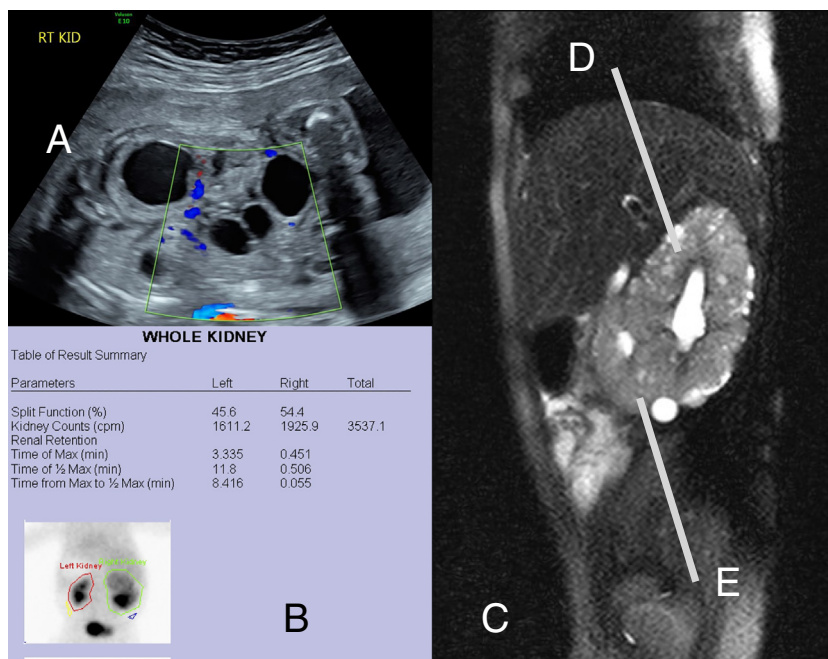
Antenatally suspected large right MCDK, postnatally large upper moiety MCDK with hidden lower moiety with preserved function. A: Antenatal USS appearance of right suspected MCDK at 30 weeks gestation. B: Mag 3 shows previously undetected lower moiety with 54% split renal function. C: MRI confirms large upper moiety segmental MCDK (D) and small lower moiety with functioning parenchyma (E).
